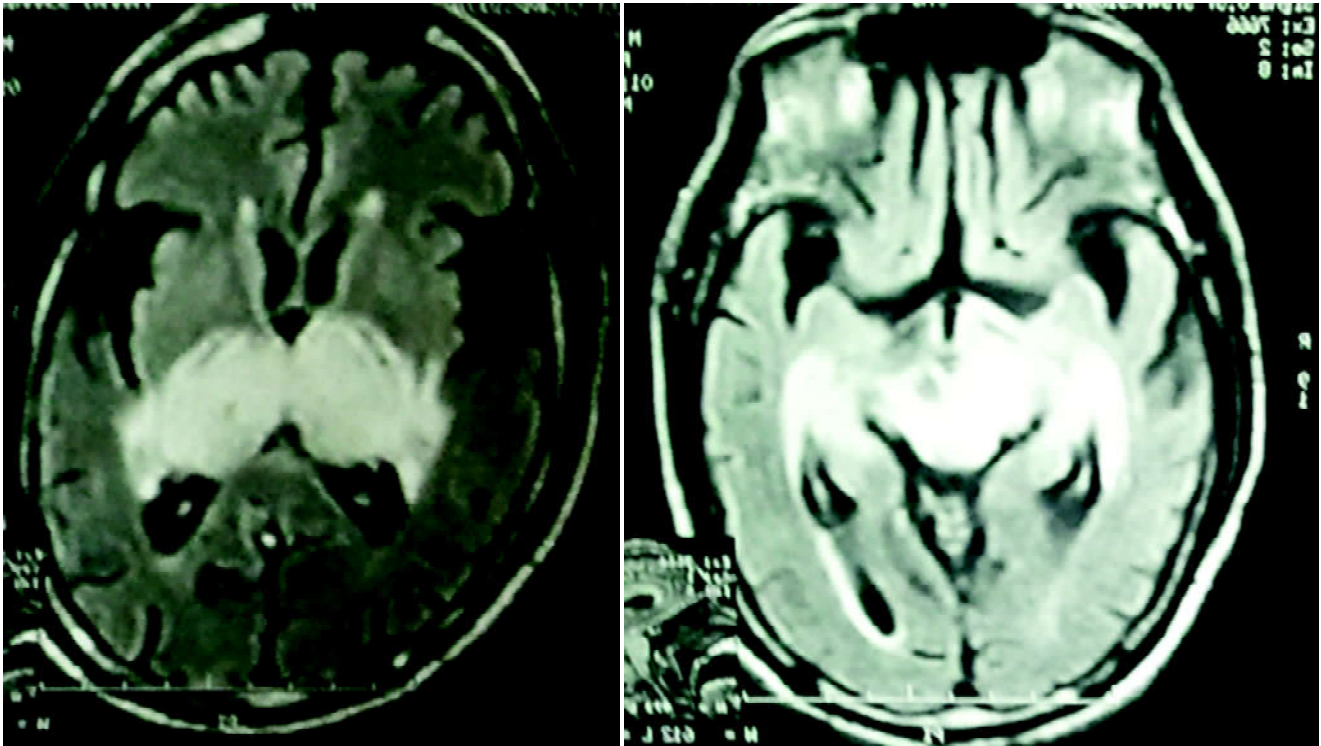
MRI findings: Hyperintensity of mid-brain and thalamus.
